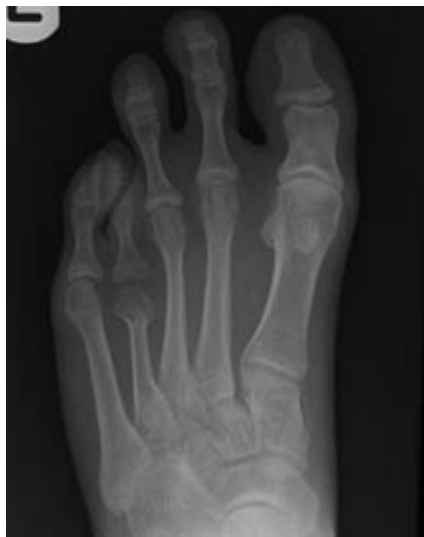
AP radiograph of the left foot showing 7 mm shortening of the 4th metatarsal compared to the 5th metatarsal head.
